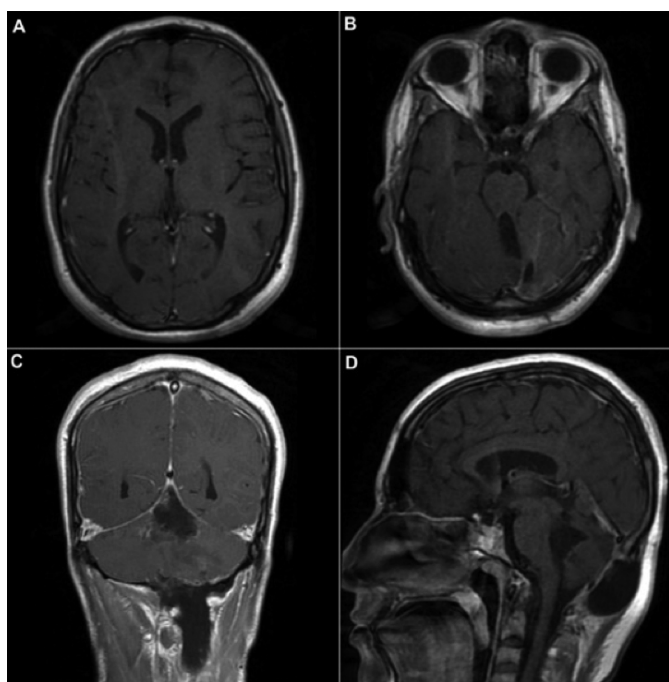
Postoperative 9-month follow-up MRI, contrast-enhanced T1-weighted MRI images; (A) Axial, level of the third ventricle; (B) Axial, level of the cerebellum; (C) Coronal; (D) Sagittal.
